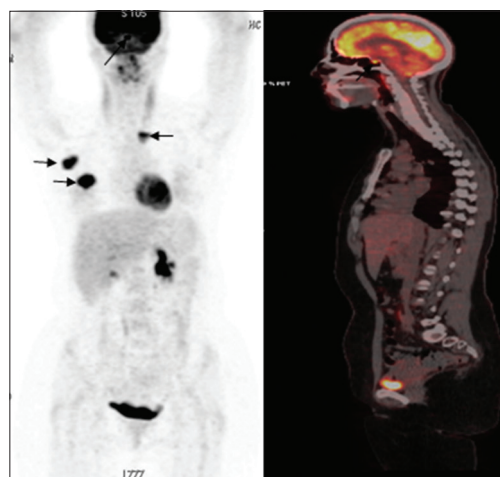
Positron emission tomography/computed tomography with ^{18}F -fluorodeoxyglucose, maximum intensity projection, and sagittal fusion image showing multiple hypermetabolic foci (indicated by arrows)
